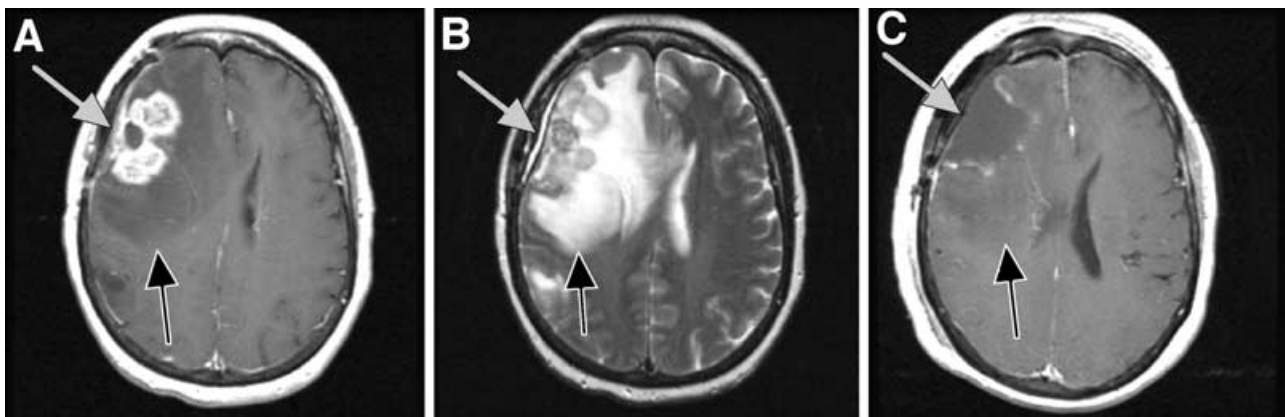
Pre- and postoperative MRI images of glioblastoma multiforme (GBM) tumor. (A) Pre-operative T1-weighted MRI scan of GBM tumor. The area of contrast enhancement (grey arrow) corresponds to frank tumor with disruption of the blood–brain barrier. The surrounding brain tissue into which GBM cells are invading is clearly edematous (black arrow). (B) Pre-operative T2-weighted MRI scan of the same tumor. In this series, the frank tumor (grey arrow) and the surrounding brain tissue with edema and invading tumor cells (black arrow) are both bright. Note that the abnormal signal area extends across the corpus callosum into the contralateral hemisphere. (C) Post-operative T1-weighted MRI scan. The region of frank tumor has been resected resulting in the absence of contrast enhancement (grey arrow) but residual areas of edema and residual infiltrating tumor remain (black arrow).
